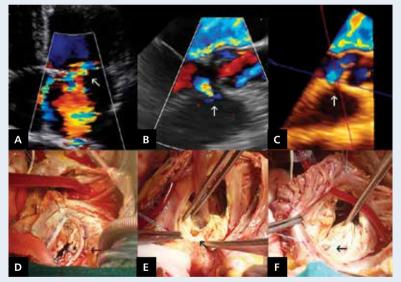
A. Apical 4-chamber echocardiogram view showing severe mitral valve insufficiency (arrow); B. Two-dimensional left parasternal long axis echocardiogram view showing shunt of interventricular communication (arrow); C. Three-dimensional echocardiography image of interventricular septum defect (arrow); D. Intraoperative view of mitral valve repair by quadrangular resection of posterior mitral valve leaflet (asterisk) and ring annuloplasty (arrow); E. Intraoperative view of interventricular septal defect from right atrium (arrow); F. Surgical repair by direct closure of interventricular communication (arrow)
